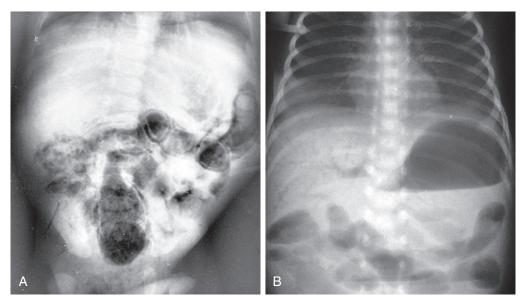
Pneumatosis intestinalis is seen most easily as linear streaks of air outlining the bowel and producing concentric rings when viewed on end. More common, however, is the bubbly pattern seen in the right iliac fossa in this patient, appearing like stool within the lumen (A). In severely affected infants, gas may fill the portal system and produce visible streaks of air on abdominal plain film (B).
